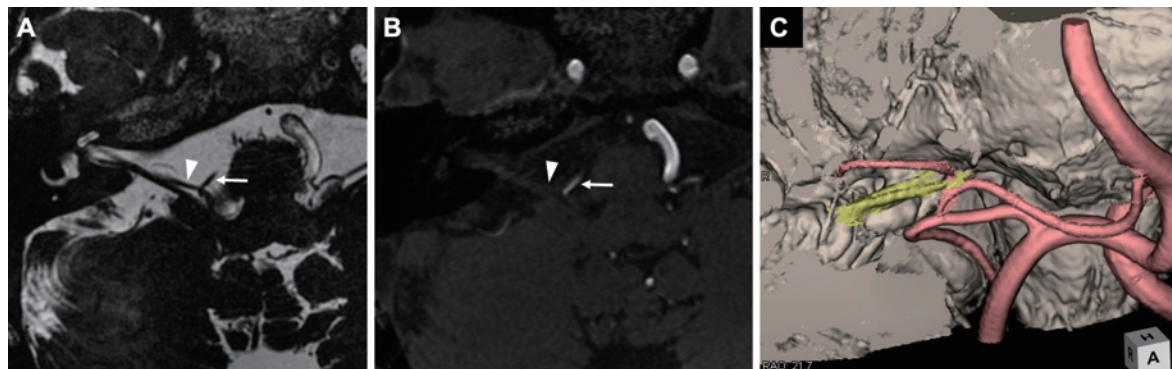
Preoperative MRI. (A) Heavy T2-weighted image and (B) MRA showed that the right AICA (white arrow) was penetrating the right facial nerve (white arrowhead). (C) The 3D reconstruction of MRI images. It seemed that the AICA was running between the facial nerve and the vestibulocochlear nerve.
